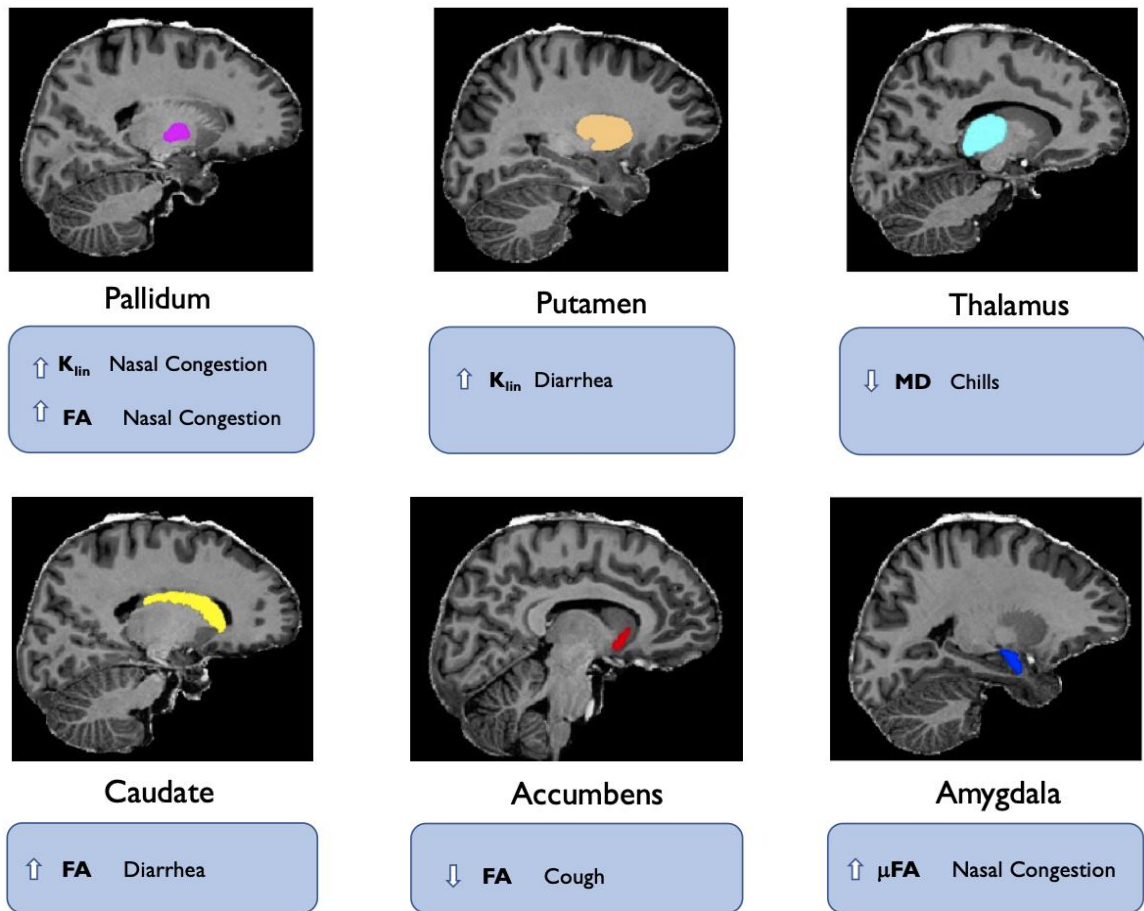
Significant diffusion MRI findings in subcortical structures related to symptoms present at the time of acute illness
